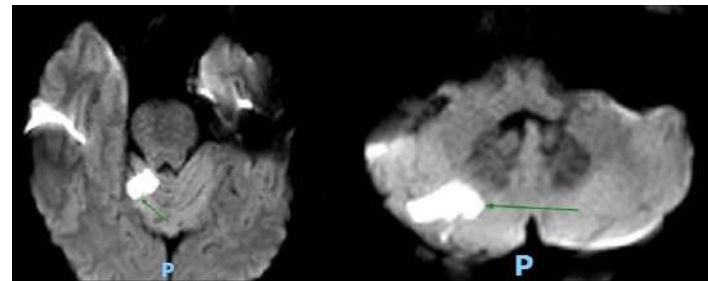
MRI scan Oct 2022 showing Acute infarcts involving the right half of the cerebellar hemisphere, with subacute infarcts in the right parietal region.
